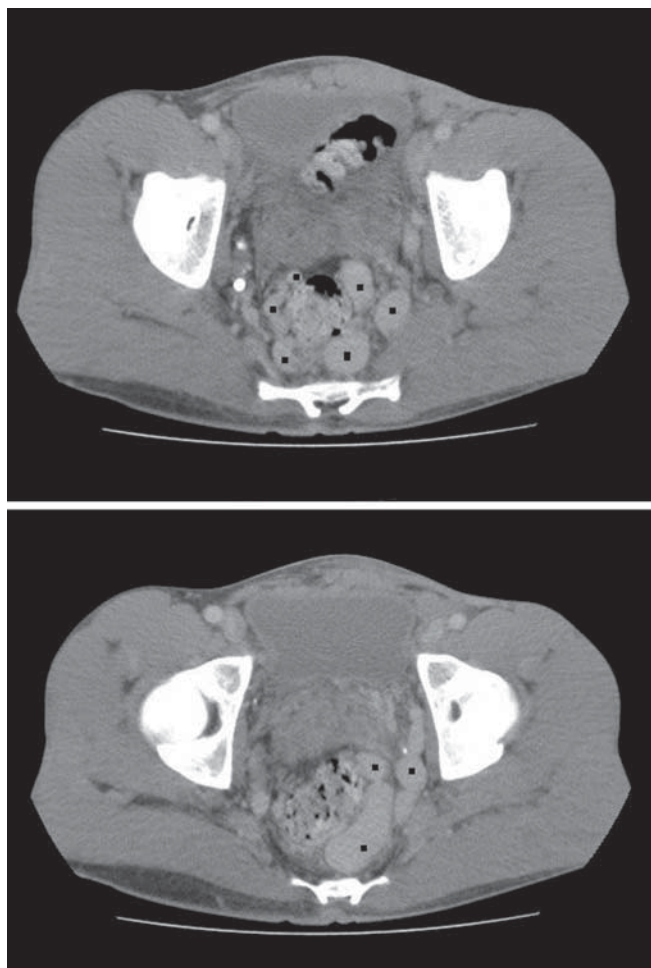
CT image of the pelvis in a patient with Proteus syndrome. The dots mark the venous anomalies (dilatated veins) around the ano-rectum
